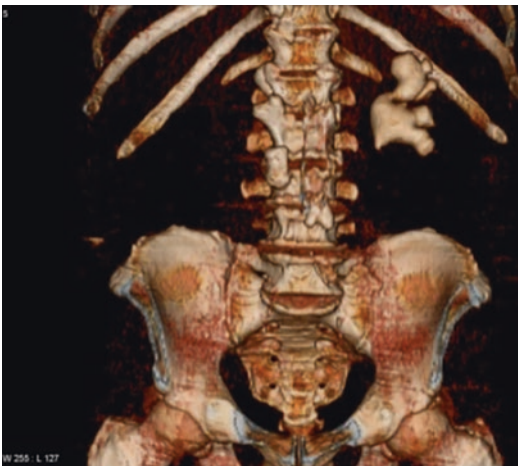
3-D CT in complex stone scenario. (CT with 3-D reconstruction of large calcium oxalate monohydrate staghorn stone. 3-D reformatting helped deciding best route of access in an endoscopic intrarenal surgical [ECIRS] procedure)
